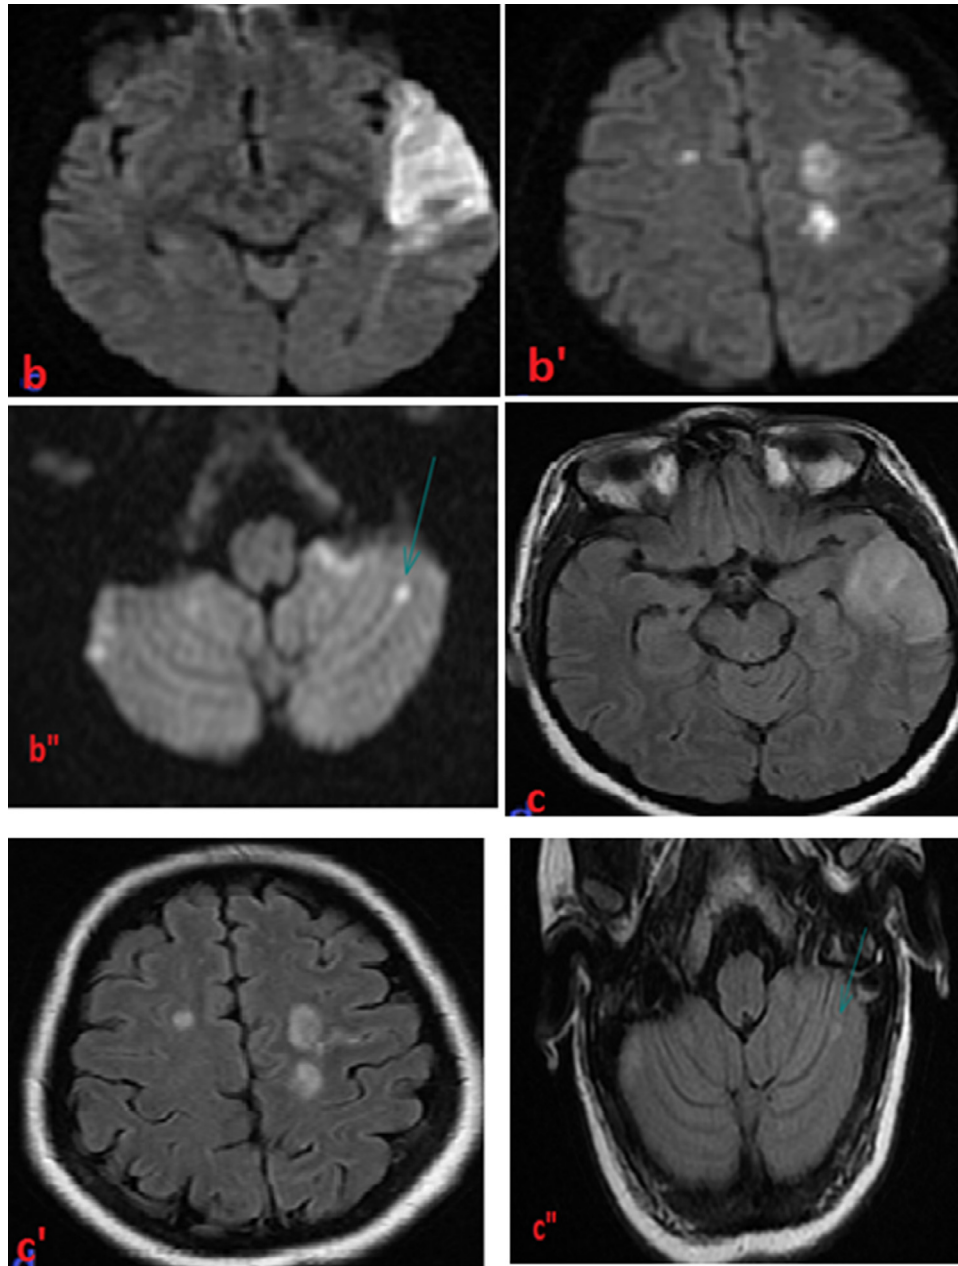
Axial MRI sections in diffusion sequence (b)(b')(b''), T2 FLAIR showing multiple bilateral sylvian subacute ischemic strokes and left PICA. Absence of hemorrhagic remodeling. (c)(c')(c'').
